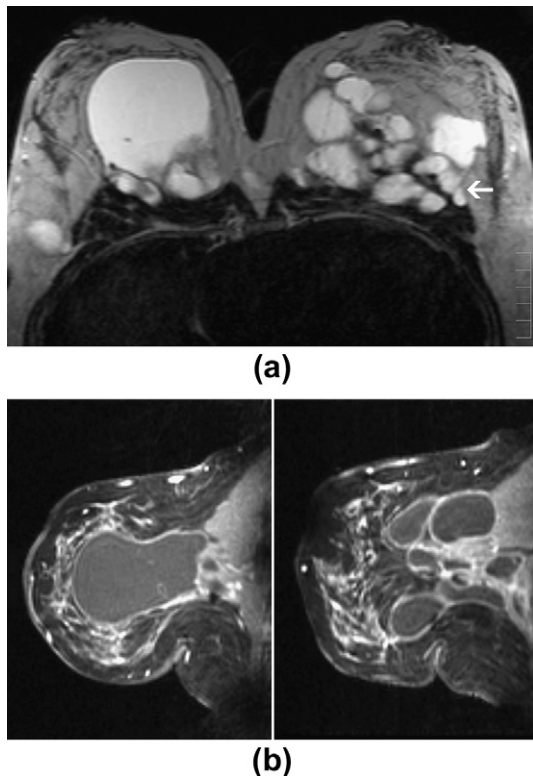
(a) Axial, T2-weighted and (b) sagittal, T1-weighted, fat-saturated, post-gadolinium sequences demonstrate a large collection of Macrolane within the parenchyma on the right with multiple smaller collections in the left parenchyma and pectoralis muscle bilaterally. Deposits are high signal intensity on T2, low signal intensity on T1 and demonstrate rim enhancement post contrast medium administration.
